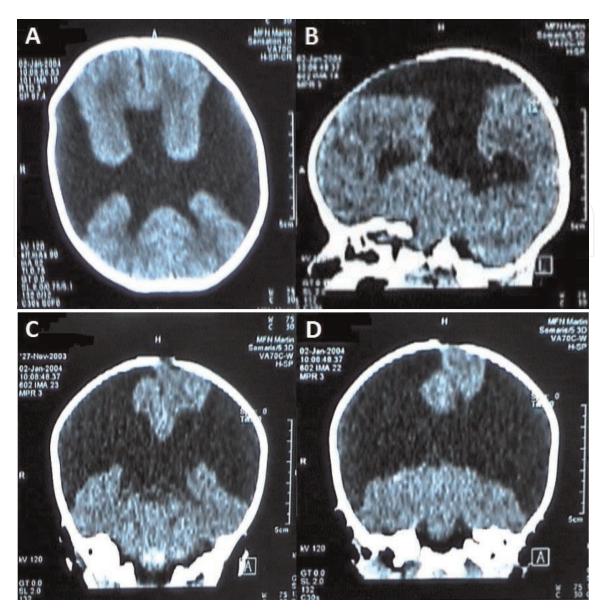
CT examination of the infant with schizencephaly.
